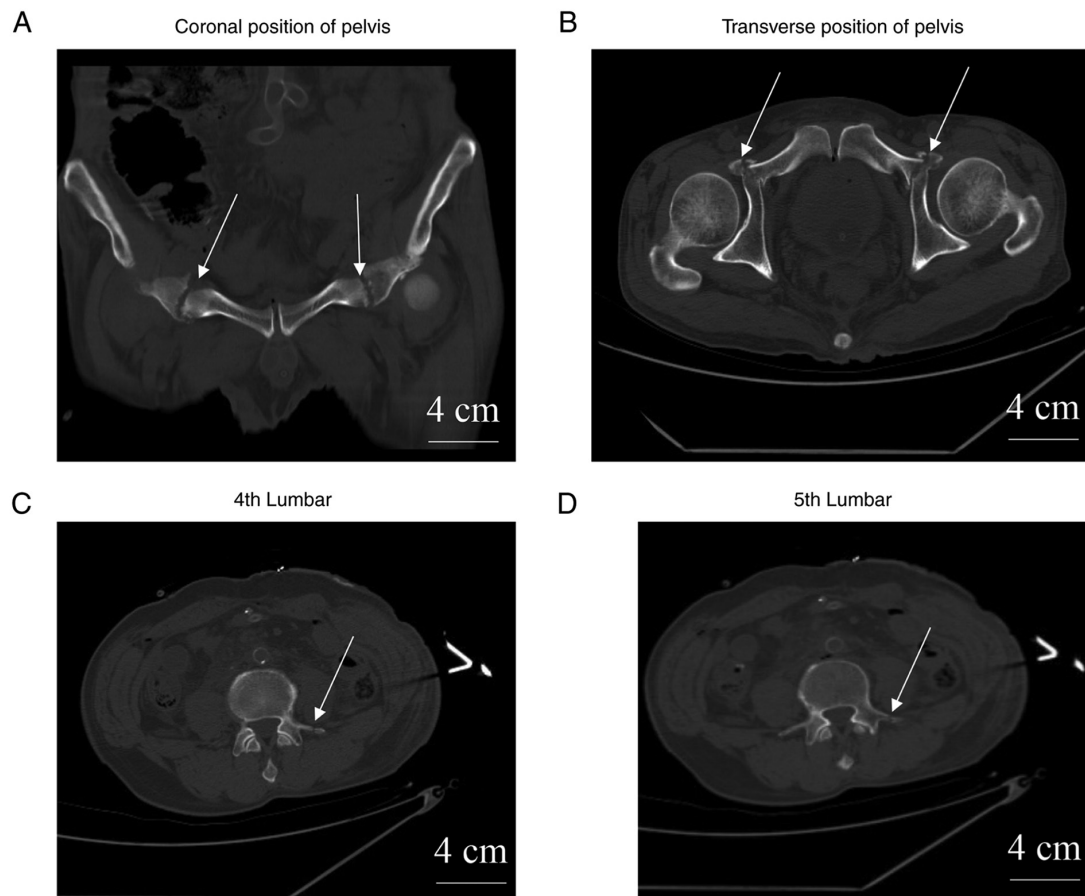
Computed tomography scan shows the fractures of pelvis and the 4th and 5th lumbar. (A) Coronal position of the pelvis fracture. (B) Transverse position of the pelvis fracture. (C) Fracture of the 4th lumbar. (D) Fracture of the 5th lumbar. White arrows indicate the fracture points.
